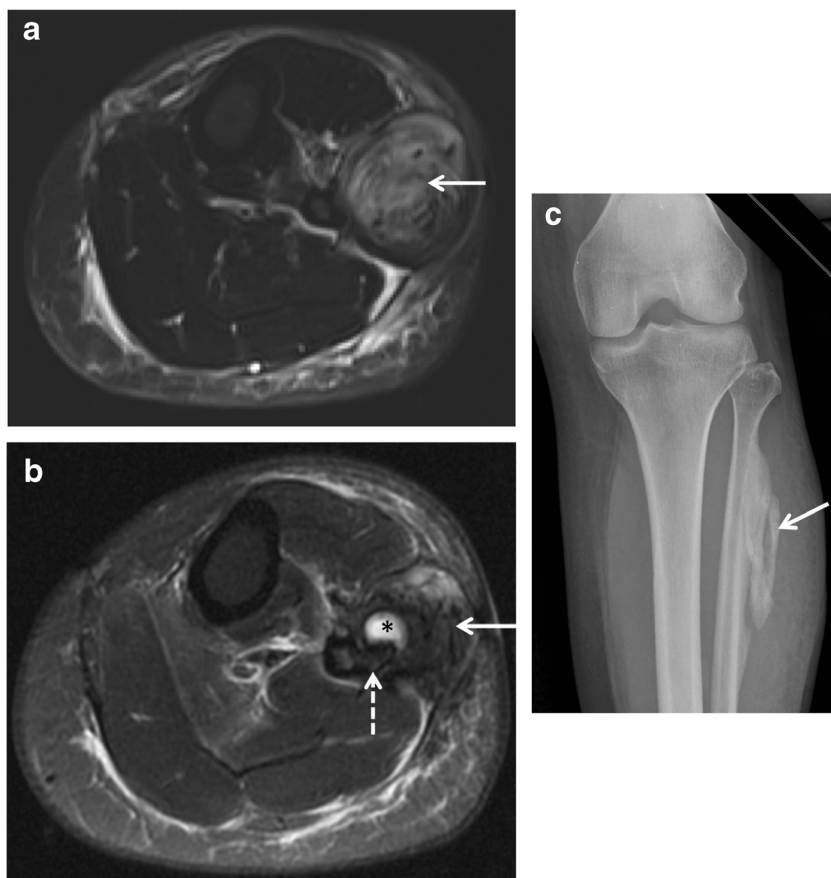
Strain of the peroneus longus muscle due to proximal tibiofibular joint injury in a 44-year-old female following twisting injury. Axial T2-weighted fat-saturated MR image shows muscle strains at the anterior and lateral compartments, including the peroneus longus muscle (*solid arrow*)
